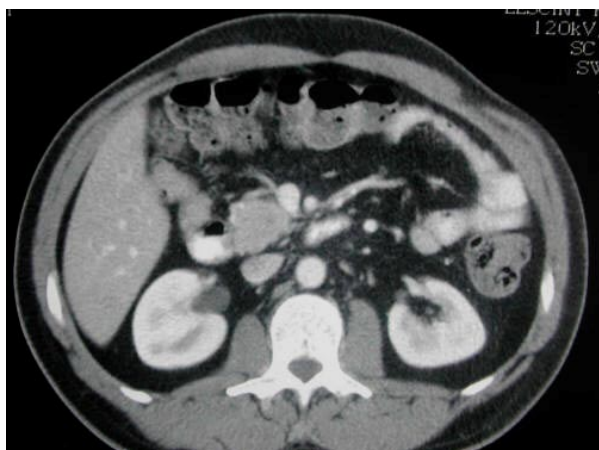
Helical CT aspect of a pancreatic neuroendocrine tumour: hyperdense mass in uncinus process.
